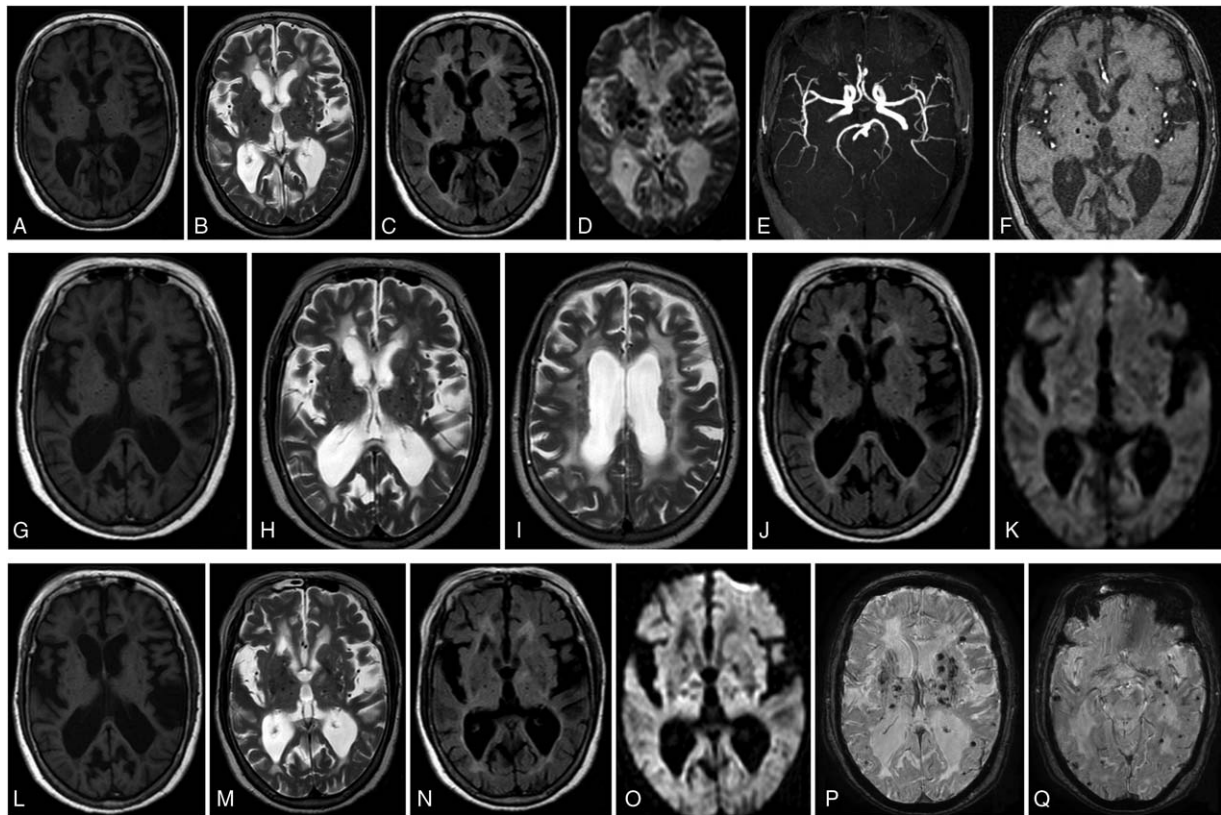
Magnetic resonance evolution of the case. Brain MRI of the case obtained for the first time in April 2015 (A–F) indicates the left basal ganglia, thalamus and cerebellum have multiple small circular abnormal signals, the T1WI, T2WI, and FLAIR exhibited low signals in the bilateral basal ganglia and thalamus, and an enhanced scan indicated lesion visible edge enhancements. Semioval center bilateral basal ganglia and other T1WIs indicate multiple punctate or low signals, T2WI high signals, and a FLAIR sequence with a clear display. On the FLAIR sequence, next to the bilateral lateral symmetry, a large sheet of white matter high signal was identified. Next brain MRI obtained in September 2015 (G–K) indicates which compared with April 2015, the right thalamus T2 high signal disappeared. The third MRI obtained in April 2016 (L–Q) indicates multiple punctate susceptibility effects on the SWI sequence in the basal ganglia, which is similar findings with 2015. FLAIR = fluid-attenuated inversion recovery, MRI = magnetic resonance imaging, SWI = susceptibility-weighted imaging, T2WI = T2-weighted image.
